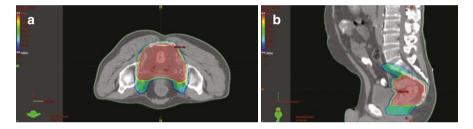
(a) Dose distributions of 4275–5040 cGy in the axial plane of CT scan performed in the prone position. (b) Dose distributions of 4275–5040 cGy in sagittal plane
